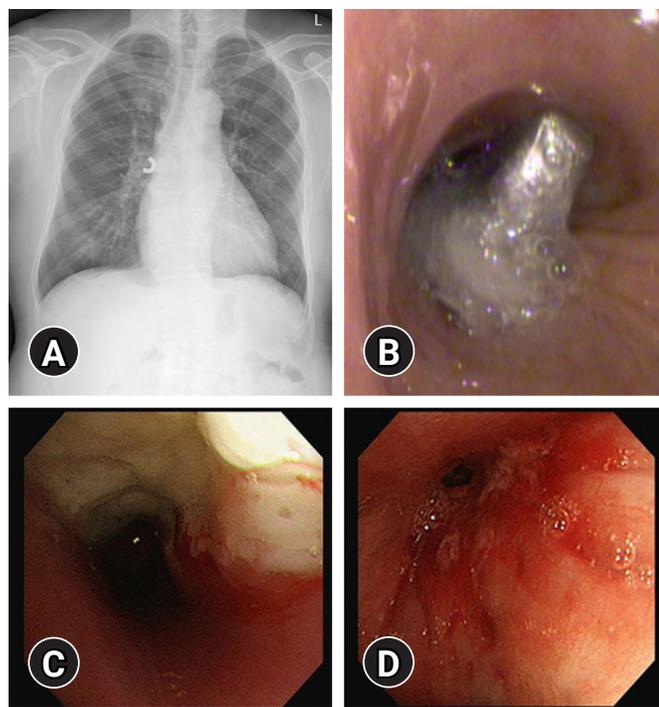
Radiographic and bronchoscopic findings of foreign body (A, B), bronchogenic carcinoma (C), and endobronchial tuberculosis (D).
